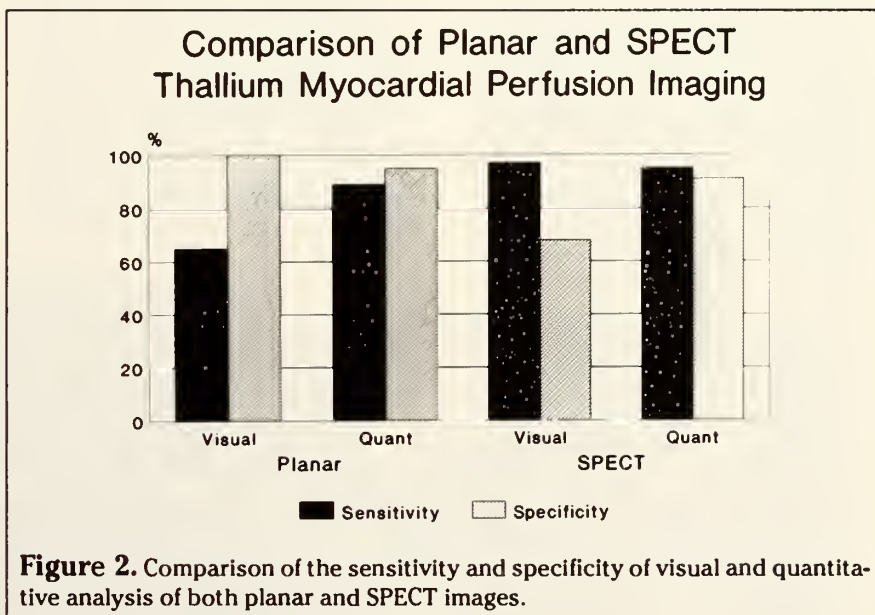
Comparison of the sensitivity and specificity of visual and quantitative analysis of both planar and SPECT images.
